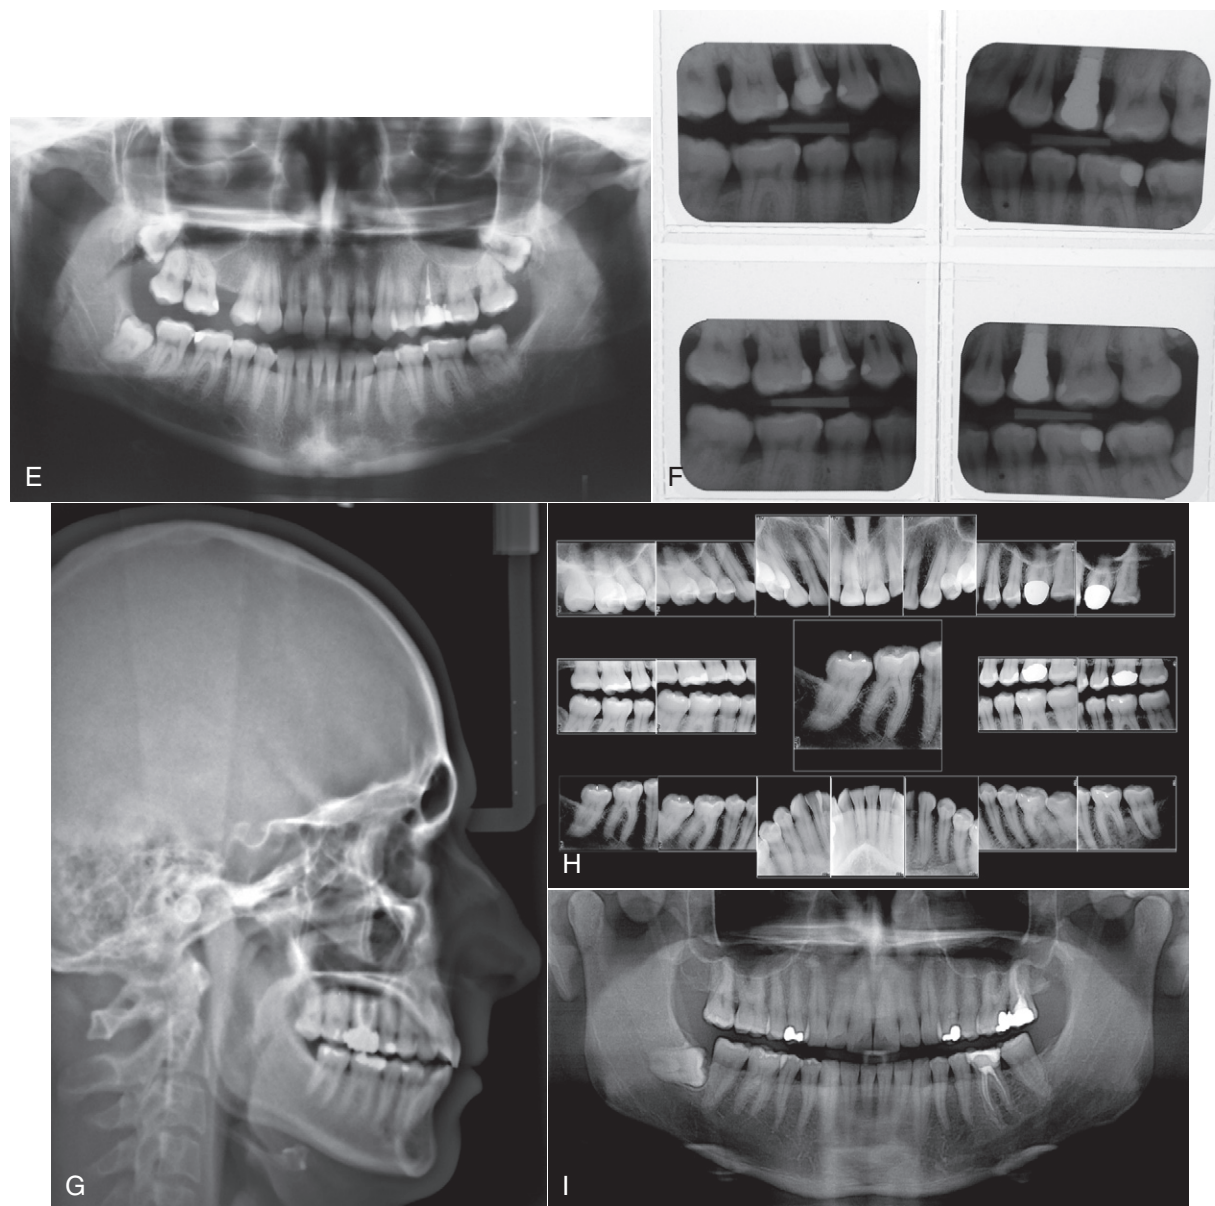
cont'd E and F, Analog radiographs. G to I, Digital radiographs.
